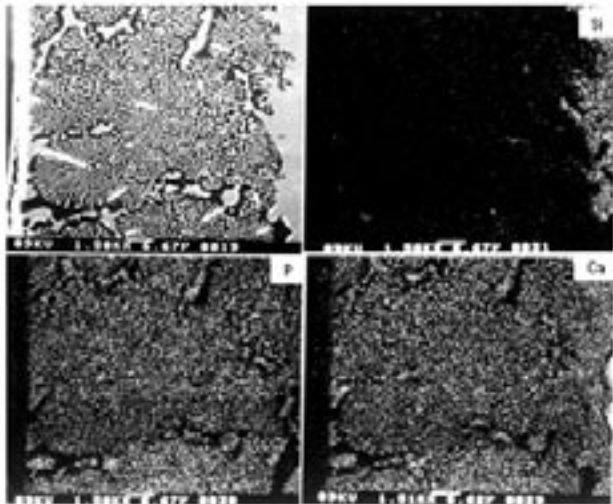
SEM image of a cross-section of the Bioeutectic<sup>®</sup> after one week soaking in SBF and Si, P, and Ca X-ray maps.
